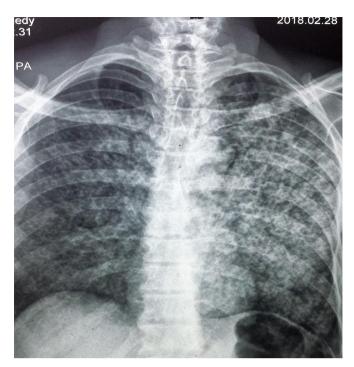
Frontal chest radiograph showing well-defined and diffuse micronodular opacities in both lung fields.
